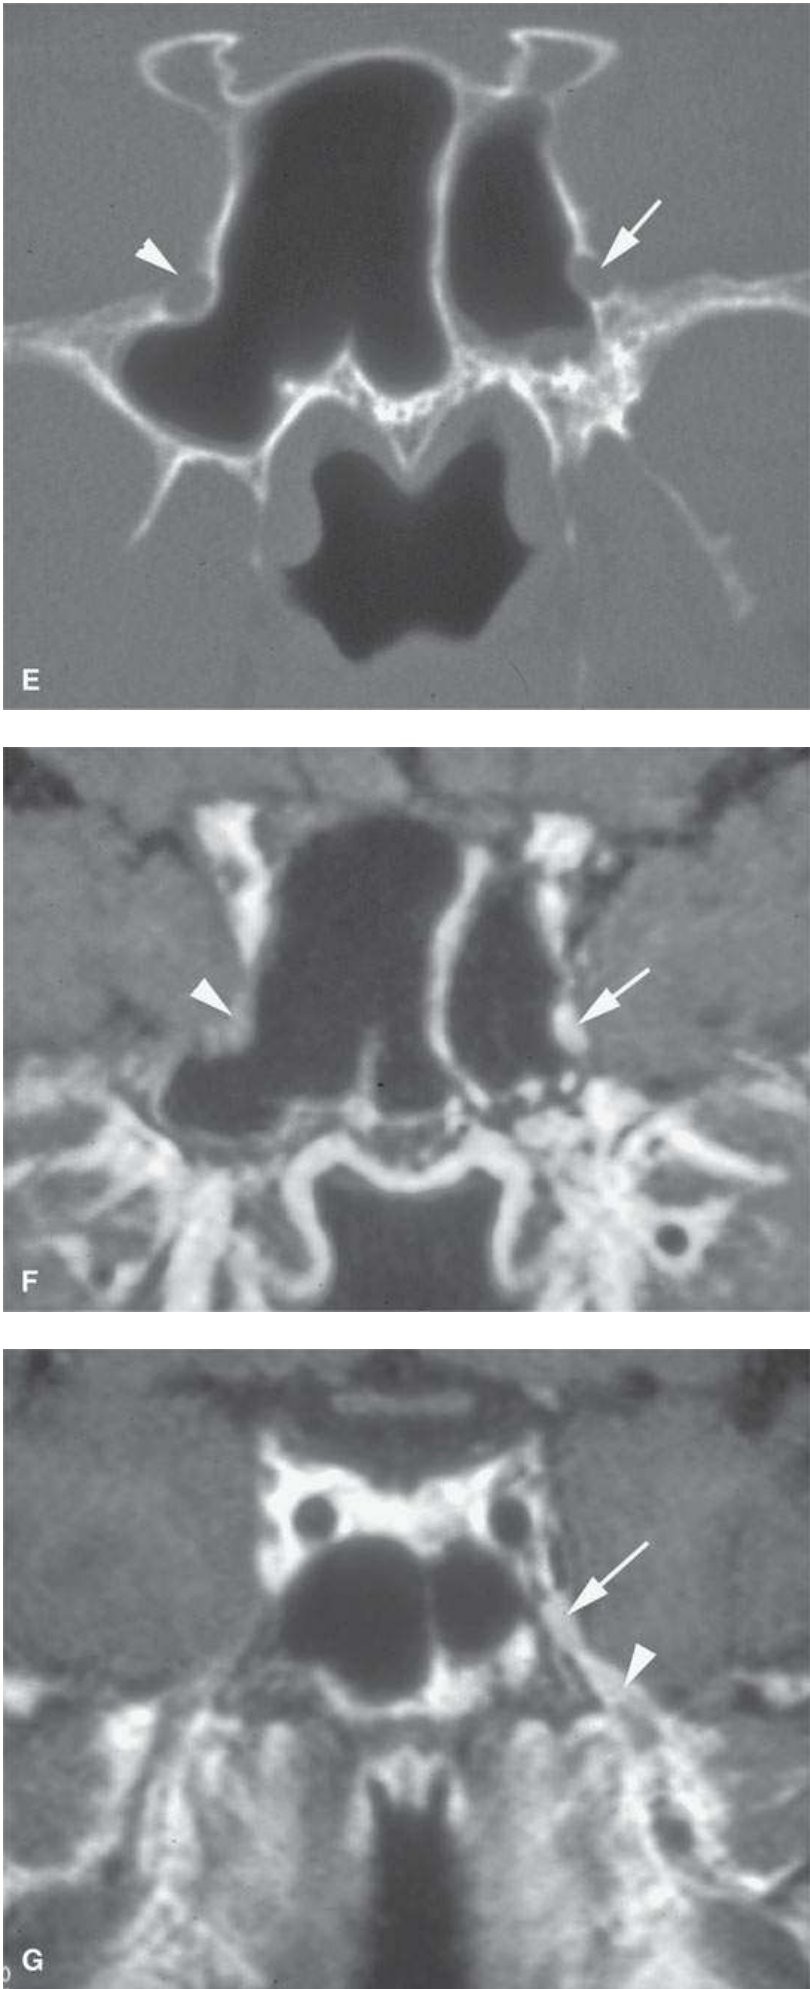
A patient with gingivobuccal sulcus cancer (*arrows in A*) with enlargement of the palatine foramina (*arrowhead in A*). B: Spread along the palatine foramina (*arrow*) compared to normal on the right (*arrowhead*). C: Continued spread to the pterygopalatine fossa (*arrow*) and along the posterior superior alveolar vessels and nerves along the posterior maxillary sinus wall (*arrowheads*). D: Continued spread to the inferior orbital fissure (*arrow*) obliterating its fat compared to the normal side (*arrowhead*). E: No definite evidence of spread along V2 in the foramen rotundum (*arrow*) compared to normal (*arrowhead*); however, compare to the magnetic resonance imaging in (fF). F: Contrast-enhanced T1-weighted (T1W) image shows definite enlargement and abnormal enhancement of V2 in the foramen rotundum (*arrow*) compared to normal side (*arrowhead*). G: Contrast-enhanced T1W image showing tumor spreading antegrade from the V2 junction with trigeminal ganglion (*arrow*) to proximal V3 (*arrowhead*).
